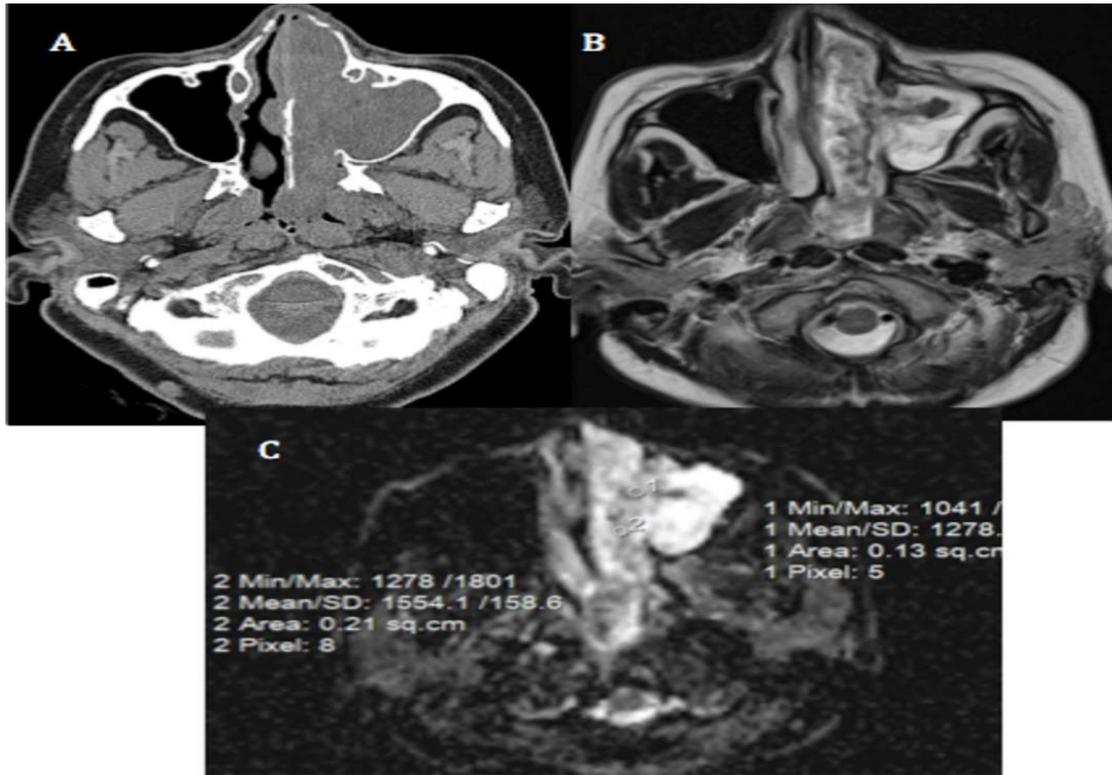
Inflammatory polyp. A) Axial CT shows polypoidal thickening involving the left nasal cavity and left maxillary sinus associated with bone remodeling of the upper nasal septum and left maxillary sinus. B) Axial T2WI shows polypoidal thickening in the left nasal cavity extending to the left maxillary sinus with retained maxillary secretion, eliciting high SI. C) Axial ADC map shows the ADC value of the first ROI (at the area of bone remodeling) = 1.2×10^{-3} mm²/s, whereas the mean ADC value of the second ROI = 1.5×10^{-3} mm²/s.
